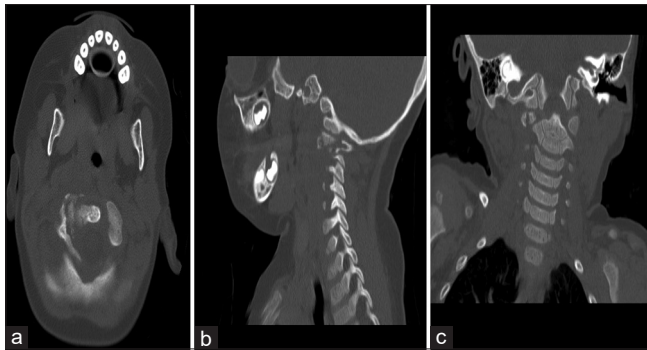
Computed tomography of the cervical spine (a) axial, (b) sagittal, and (c) coronal images showing a right-sided type III atlas fracture with an overhang of C1 on C2
